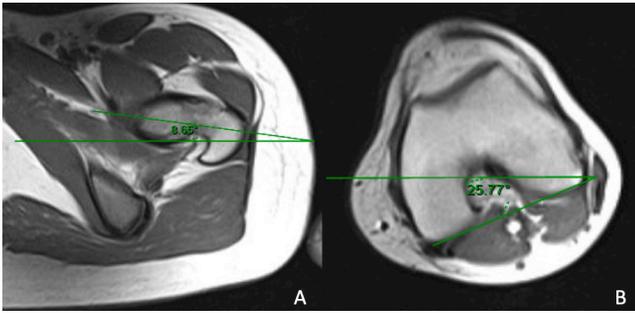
Depiction of femoral version of the right lower extremity on preoperative magnetic resonance image (MRI), which demonstrate the angles between lines through the proximal femoral neck (A) and posterior femoral condyles (B) relative to the horizontal axis, totaling 34.42 degrees.
